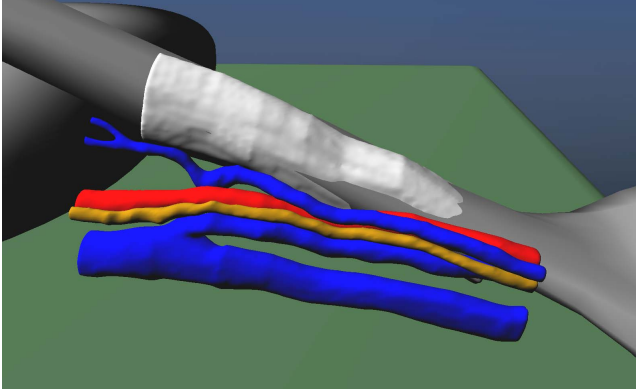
Isosurfaces of ultrasound data roughly aligned with the skeleton of the virtual patient model.
